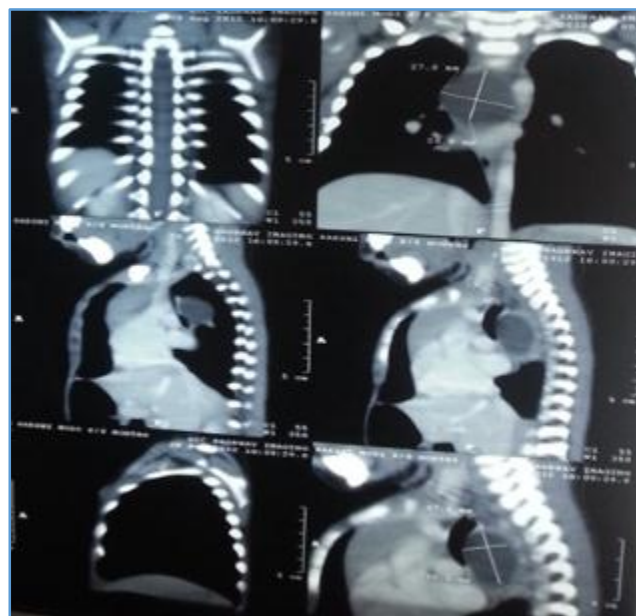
CT scan showing Bronchogenic cyst
